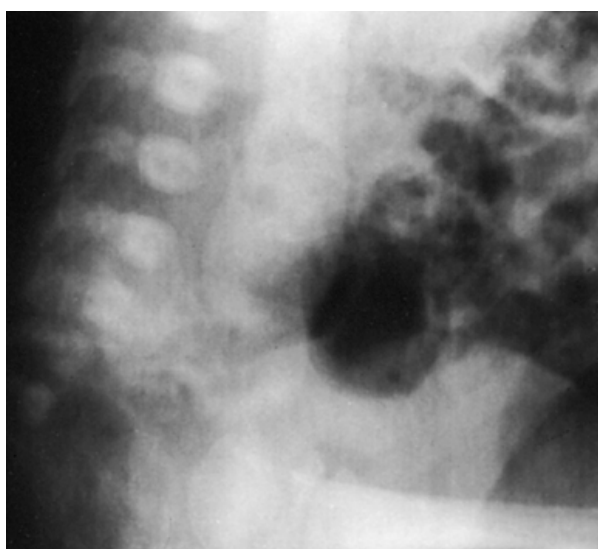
10. Midureteral stricture in a solitary kidney discovered in a prenatal ultrasound. Lateral, delayed film during intravenous pyelography.
